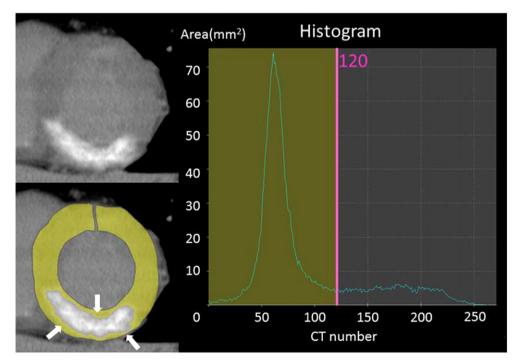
Definition of delayed contrast-enhanced MDCT area. We defined the areas with a CT number more than the maximum CT number of normal myocardium as delayed contrast-enhanced myocardium areas (arrows). MDCT, multidetector computed tomography.
